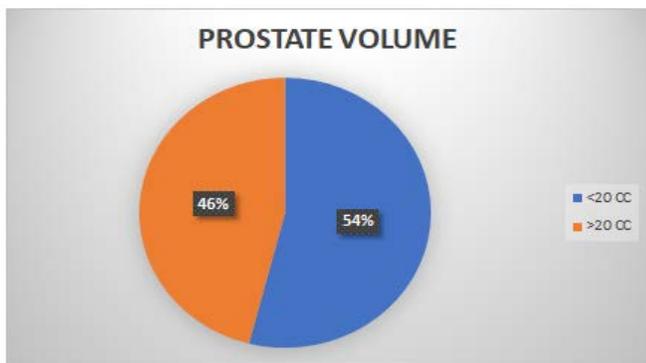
Ultrasonographic Prostate Volume
